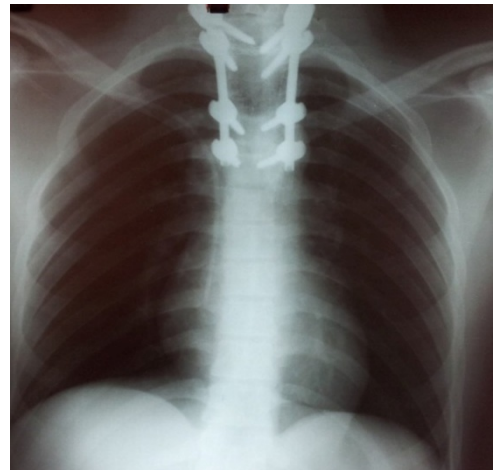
Radiography anteroposterior (AP) of the thoracic column, showing adequate postoperative coronal alignment and good positioning of lateral mass screws after laminectomy, en bloc resection of the T3 lesion and posterior stabilization of T1 to T5 with instrumented fusion
